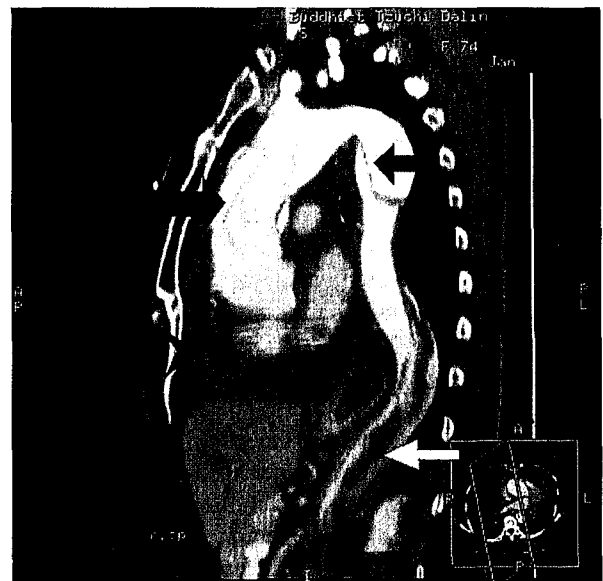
An oblique sagittal reformatted CT image shows a pericardial hematoma (arrow head) and intimal flap (black and white arrows) extensions from the ascending aorta to the abdominal aorta. The white arrow shows the intimal flap with hematoma.
